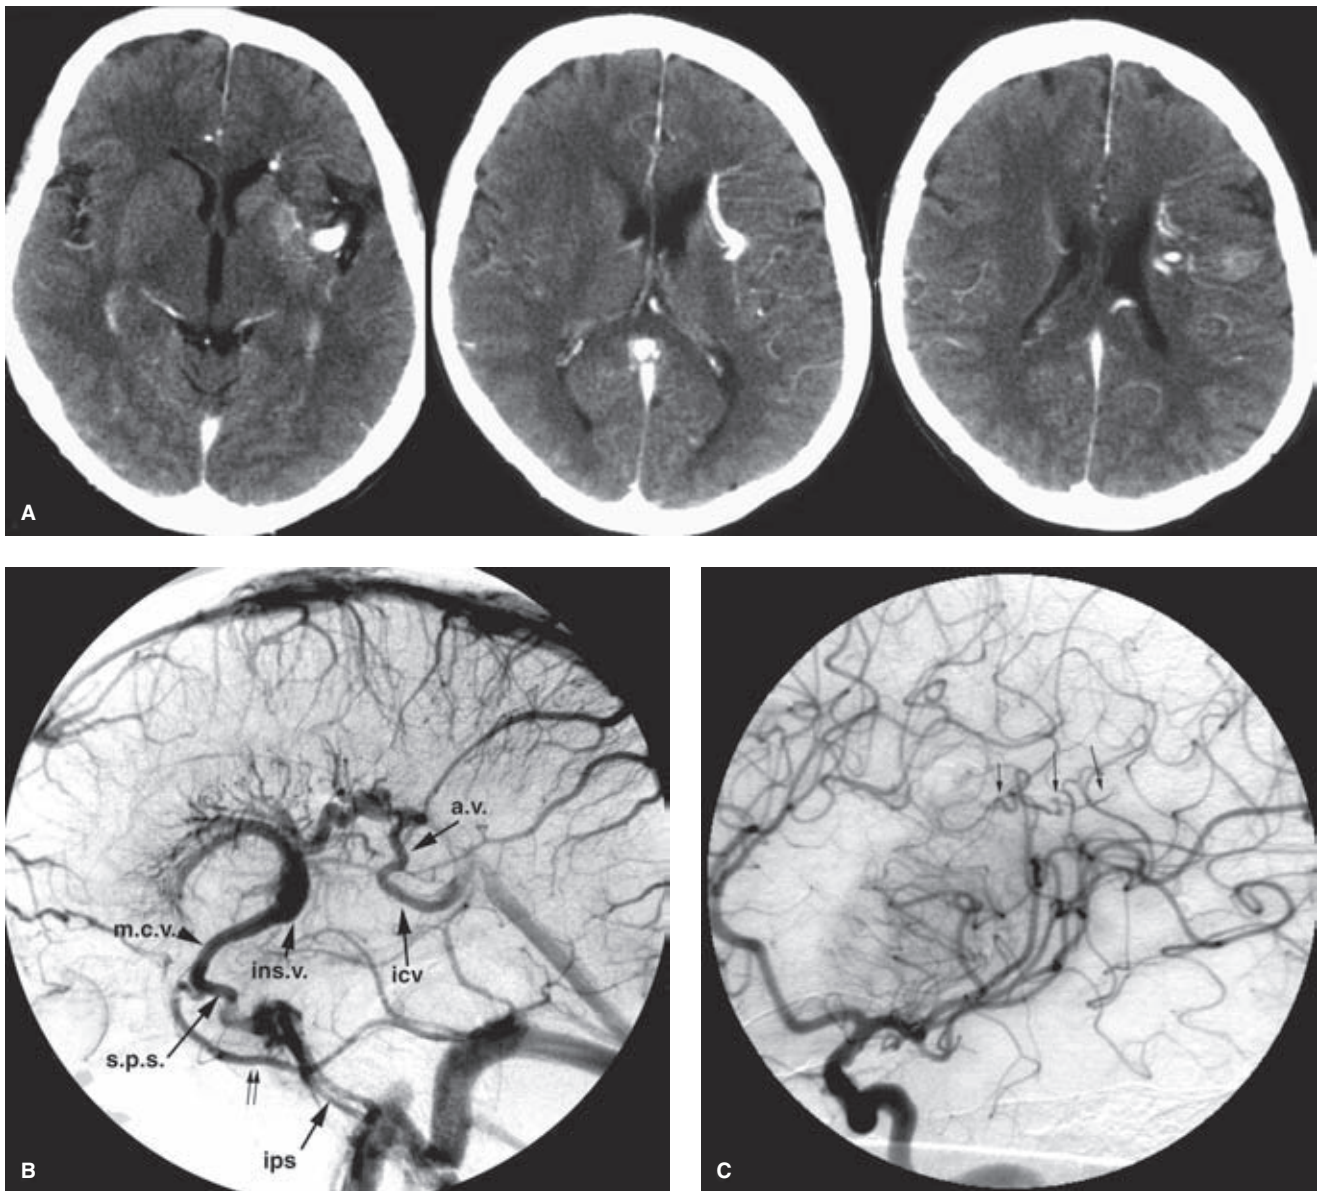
(A–C) Mixed vascular lesion. A: A contrast-enhanced CT demonstrates a typical appearance of a venous anomaly of the left frontal lobe draining centrifugally to an insular vein. The patient presented with a large subarachnoid hemorrhage in the left Sylvian fissure some weeks prior to this CT. B: The venous phase of a left internal carotid artery injection, lateral view, confirms the finding. An extensive anomaly of venous drainage in the left hemisphere drains to an insular vein (*ins.v.*) and the middle cerebral vein (*m.c.v.*). The anterior components of the anomaly drain to the cavernous sinus via the ipsilateral sphenoparietal sinus (*s.p.s.*). The cavernous sinuses drain posteriorly via the inferior petrosal sinuses (*ips*). The sphenoparietal sinus also drains to the sigmoid sinus via an alternative channel (*double arrow*), which probably represents a variant dural sinus along the floor of the middle cranial fossa. The posterior aspect of the anomaly drains via an atrial vein (*a.v.*) to the internal cerebral vein (*icv*). C: An oblique magnification view of the Sylvian area from the arterial phase of the study (same patient) demonstrates fistulous opacification of a venous structure (*arrows*) directed medially. This represents a micro-AVM associated with a larger anomaly of venous drainage. The micro-AVM was almost certainly the source of the patient's Sylvian hemorrhage.
